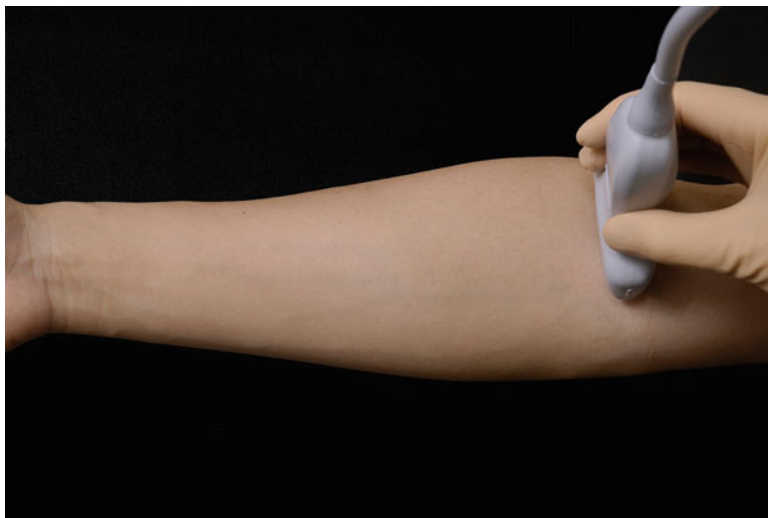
Position of the ultrasound probe for supplemental median and radial nerve blocks at the elbow
